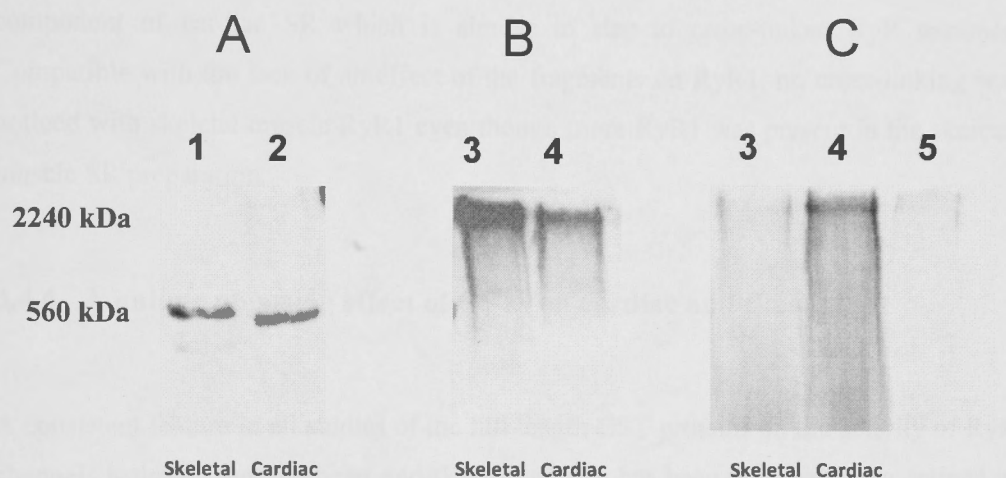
Cross-linking analysis of H5678 and RyR interactions. Panel A and B are Western blots immunodetected using anti-RyR antibody. Panel C is [^{35}S] radiography. Panel A: Skeletal (lane 1, 2 μg) and cardiac (lane 2, 60 μg) SR that has not been cross-linked. Panel B: RyR after the incubation of SR with [^{35}S] methionine labelled H5678 followed by cross linking. Lane 3, 22 μg of skeletal SR + [^{35}S] methionine, lane 4, 62 μg of cardiac SR + [^{35}S] methionine. Panel C: Radiograph of SDS-PAGE which shows [^{35}S] methionine labelled H5678 after the incubation with SR and subsequent cross-linking. Lanes 3 and 4 as same as panel B but lane 5 shows [^{35}S] H5678 after the cross linking reaction in the absence of SR (Liu *et al.*, 2009).
